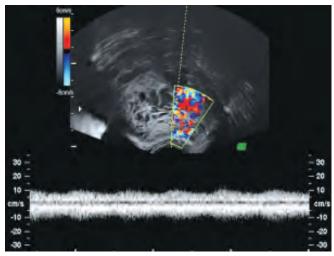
The pulsed Doppler blood flow velocity wave of Figure 11.20 tumor. The resistance index is very small because of rich blood flow in the diastolic phase. Malignant feature of tumor was supposed from the flow velocity curve *Courtesy:* U Honemeyer
